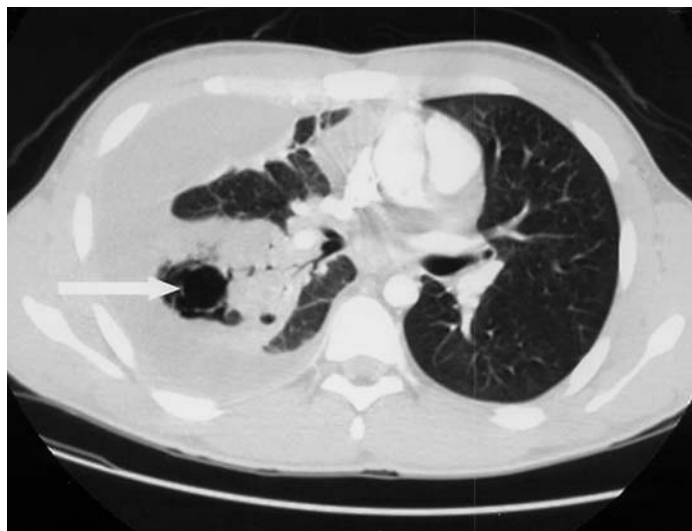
Shown is a chest CT scan from a patient with a pulmonary abscess (arrow) complicated by pleural space infection. The pleural space was drained via a chest tube thoracostomy. The lung did not completely reexpand. Sepsis was controlled with antibiotics. Decortication was not considered, because of the extensiveness of the underlying pulmonary parenchymal process.
